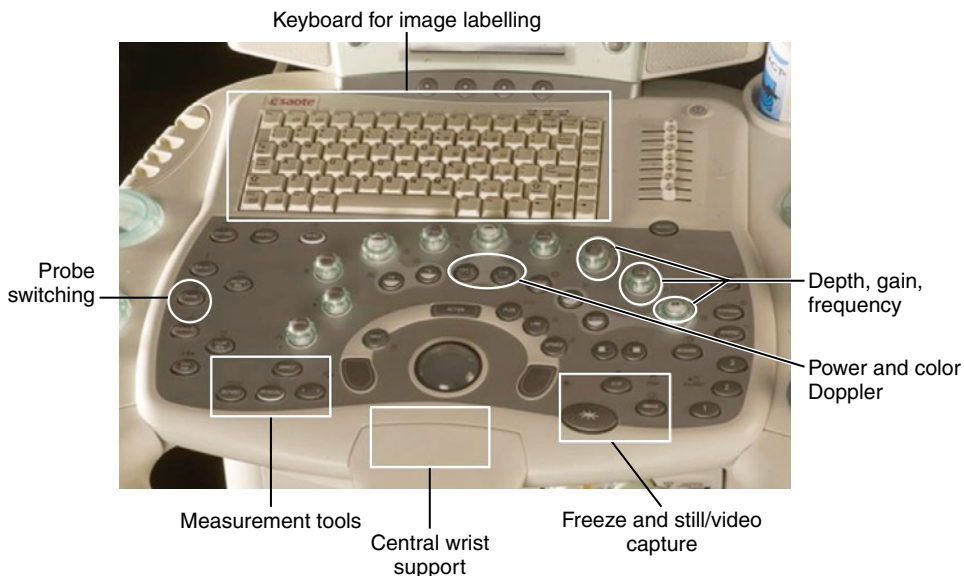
Multiple control functions are provided with most ultrasound systems, but operators tend to use a small number of controls most often. These controls should be easily accessible to achieve good ergonomic practice.
